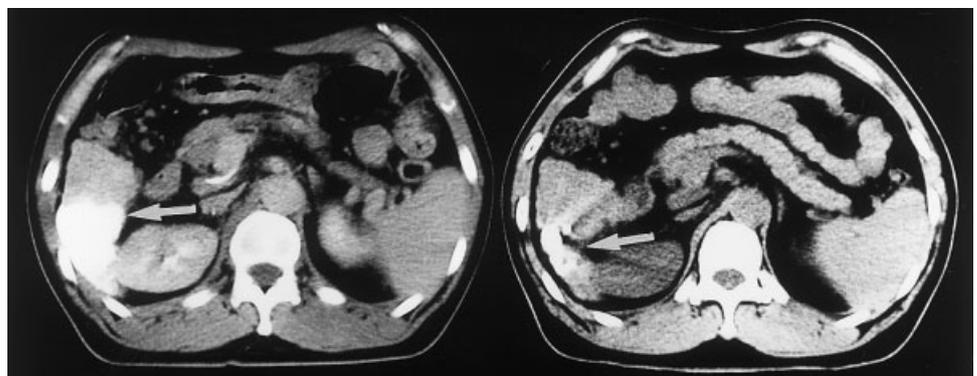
(A) In this 48-year-old woman with B-viral cirrhosis who underwent hepatic resection three times in the past and underwent radiofrequency ablation most recently (February, 2001), a 20-mm lesion was found by digital subtraction arteriography (DSA; arrow), helical computed tomography (CT) scan during hepatic arteriography and catheterization of the mesenteric artery with 20 μ g of prostaglandin E₁ (CTAP; arrow), and helical CT during hepatic arteriography (CTA; arrow) in the fifth liver segment in February, 2002. The lesion was immediately caudal to the ablated region, suggesting that this was a marginal recurrence. (B) The lesion was embolized by superselective catheterization, and lipiodol was injected until it regurgitated back into the portal vein (arrow). (C) CT scan immediately after embolization showing lipiodol deposition in and around the lesion (arrow). Serum α -fetoprotein levels dropped from 597 ng/mL to 22 ng/mL.
